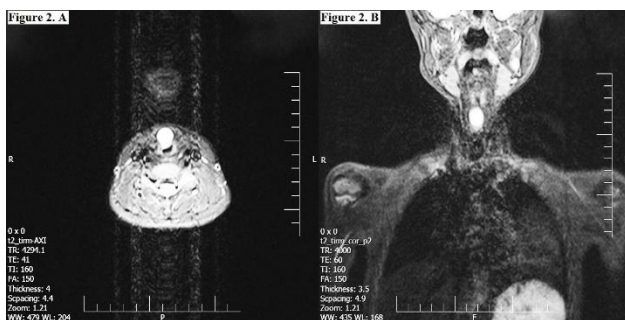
T2-weighted MRI findings. The congenital laryngeal cyst is seen as a hyperintense lesion in the axial section (A) and coronal view (B).
